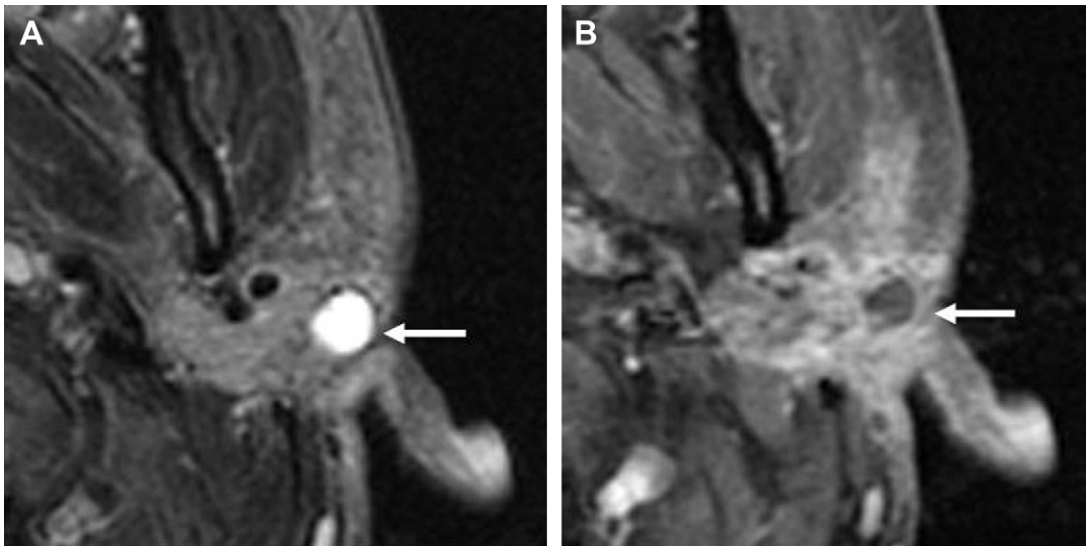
Postsurgical sialocele mimicking residual tumor. (A) Axial T2-weighted image shows a well-defined markedly T2 hyperintense collection (arrow) in the postoperative bed after left superficial parotidectomy. (B) Axial postcontrast fat-saturated T1-weighted image shows nonenhancement of the area with expected surrounding postoperative changes (arrows); this should not be mistaken for an abscess or residual/recurrent tumor. (Courtesy of L. Ginsberg, MD, Anderson Cancer Center, Houston, Texas.)
